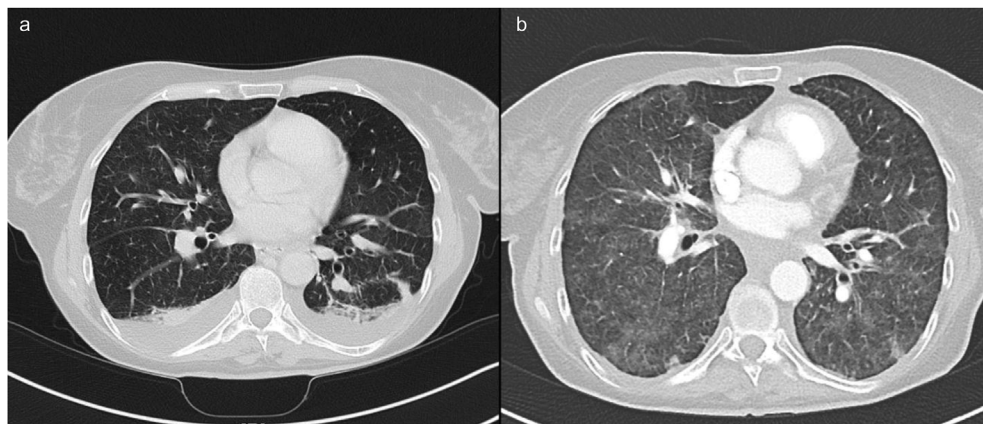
Axial planes of thoracic contrast enhanced computed tomography eight days (a) and six weeks (b) after CRS and HIPEC. Eight days after surgery both lungs are inconspicuous except for minor dystelectatic pneumonia of both lower lobes and adjacent small pleural effusions. The heart shows regular dimensions. Six weeks after CRS and HIPEC the data display extensive atypical interstitial and partly alveolar edema. No signs of pulmonary artery embolism can be detected (not visible in demonstrated plane).
